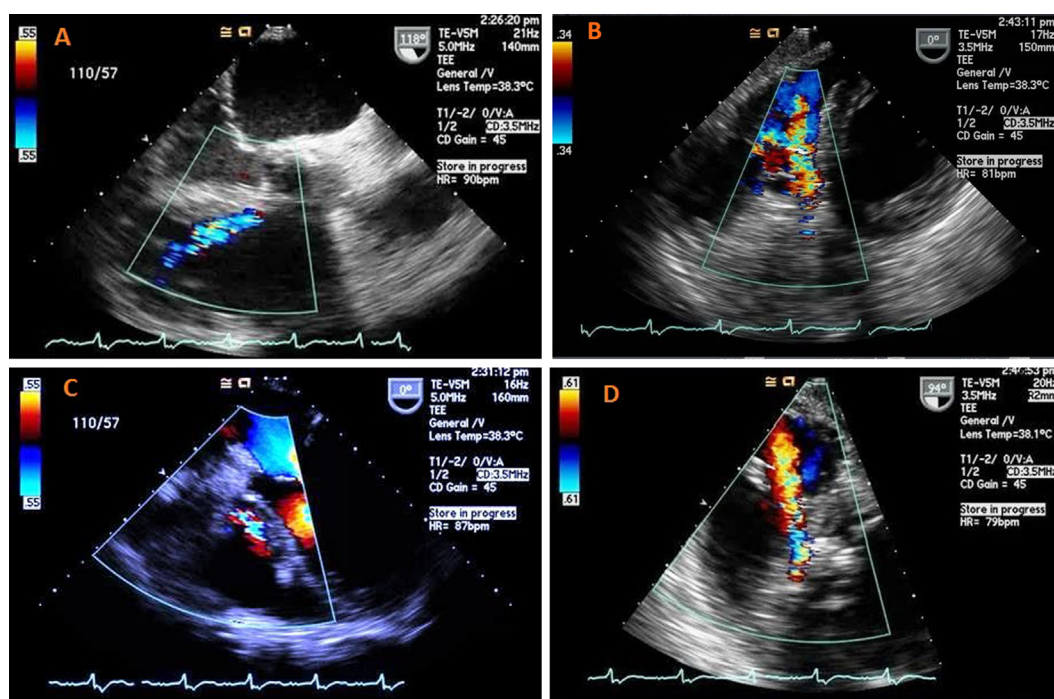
Color flow Doppler showing continuous flow through AoRV fistula. (A) Modified midesophageal, three-chamber view; (B,D) deep transgastric views; and (C) right ventricular-focused four-chamber views.
